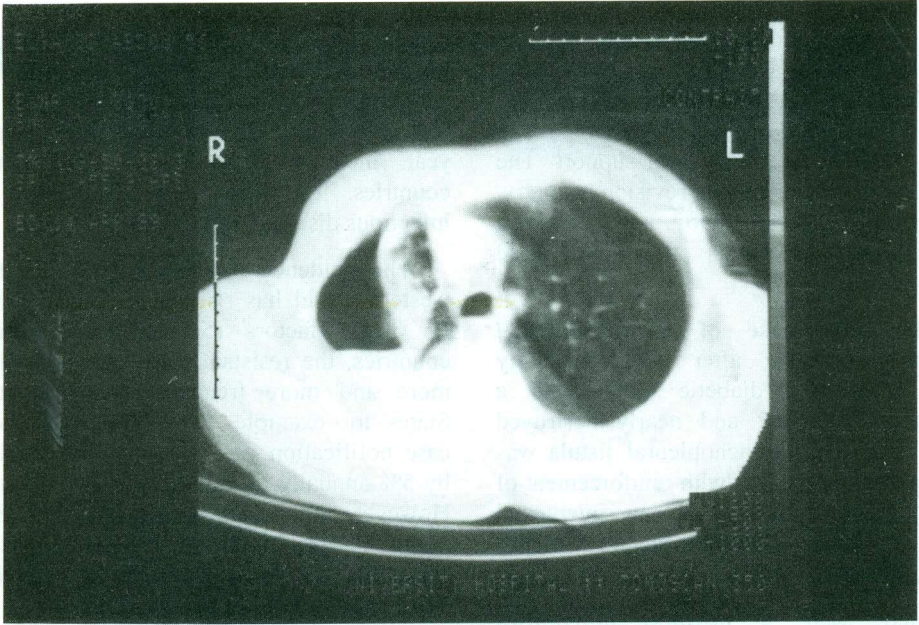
Case 2: a CT scan showing thickened pleura and collapsed destroyed lung.
